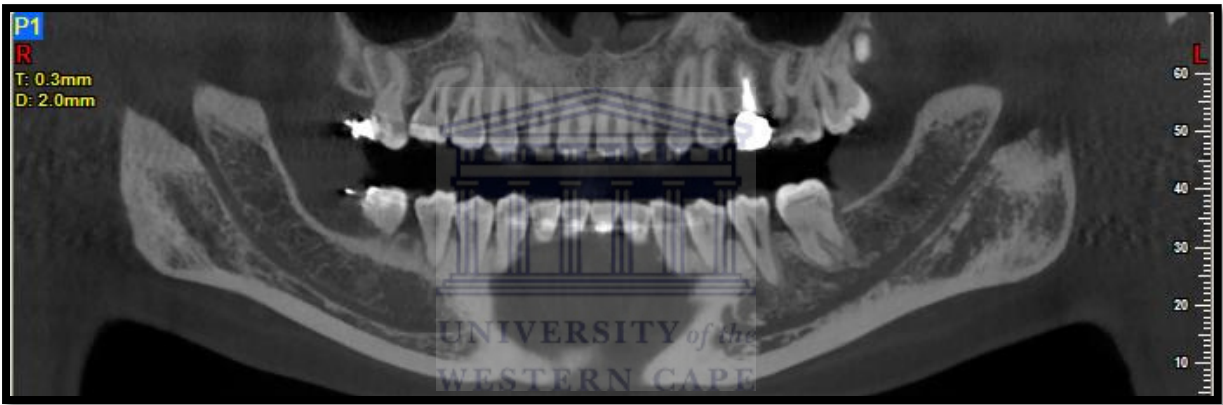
Orthopantomogram 0.3 mm thick for identification of inferior alveolar canal
